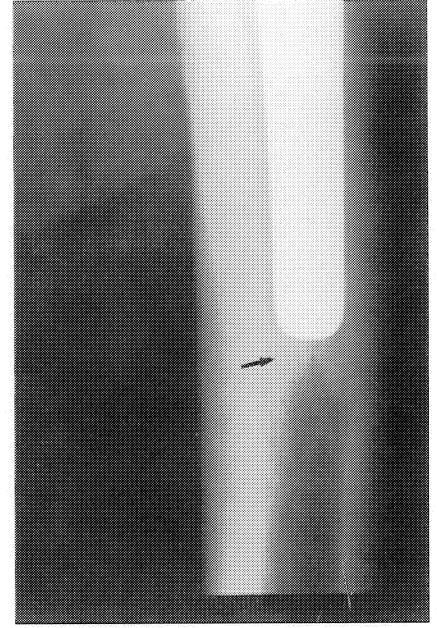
Typical femoral tip sclerosis on radiographs.
